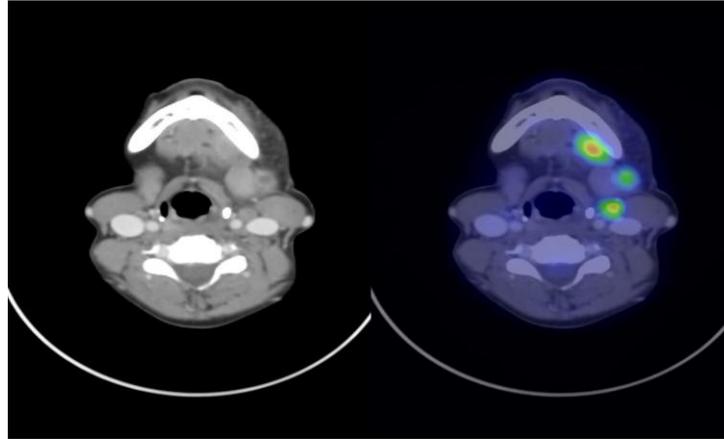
showing CECT and PET/CT of a patient with squamous cell carcinoma of alveolus
